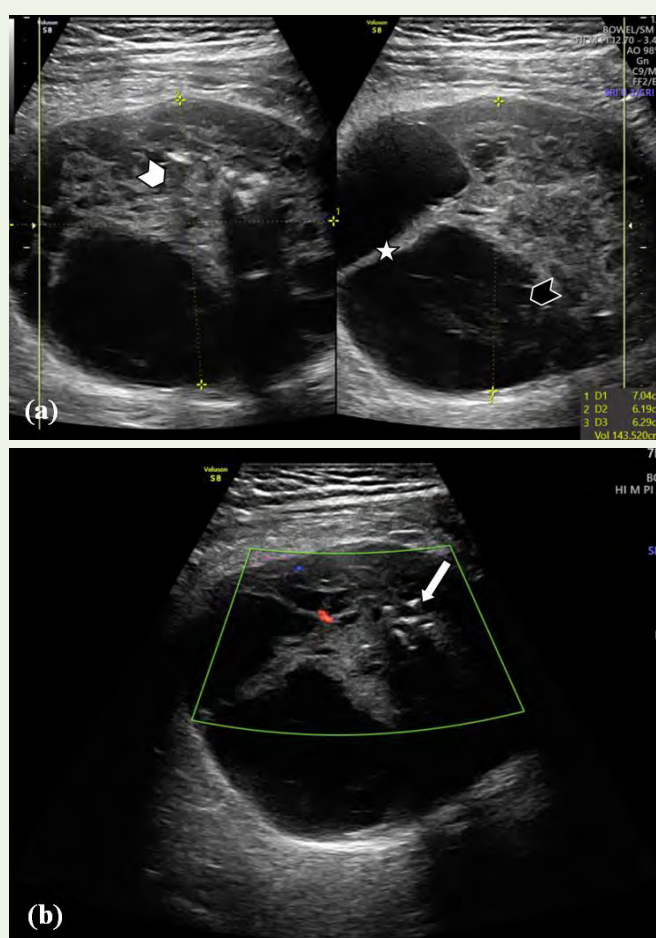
USG demonstrates (a) A well-defined, solid (white arrowhead) cystic (black arrowhead) hetero-echoic lesion with internal septations (asterisk) (b) hyperechoic foci with post acoustic shadowing- likely calcification (white arrow) and minimal internal vascularity on colour doppler.
